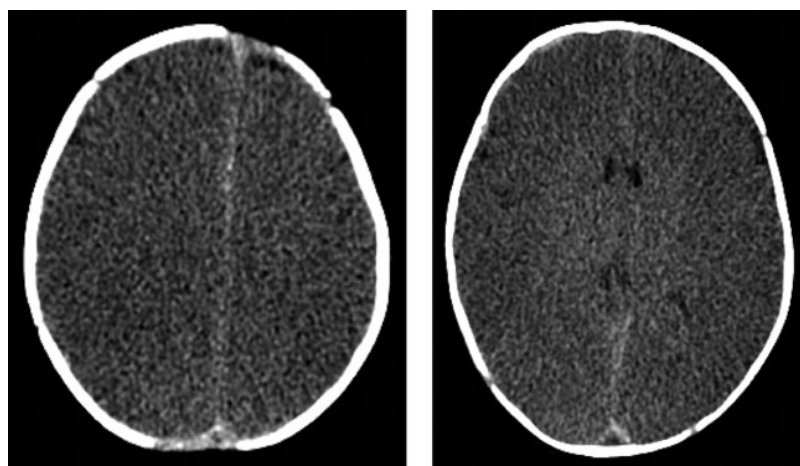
Axial non-contrast CT showing loss of gray/white differentiation in a 2-year-old boy with traumatic brain injury after non-accidental trauma. Note bilateral frontal skull fractures. The cerebral parenchyma is diffusely hypodense, with loss of the normal gray-white differentiation and global sulcal effacement. Also note small extra-axial hyperdensity within the interhemispheric fissure, compatible with hemorrhage.
